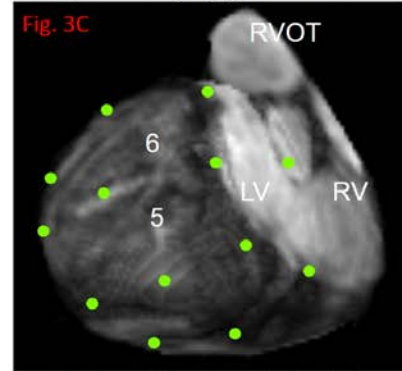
A) Standard 17-segmented scheme. In this example 8th and 9th segments include fibrosis. Therefore they are marked with a read outline. B) Example of revealing fibrosis only in 8th and 9th segments using MRI data. C) The same example of a reconstructed epicardial polygonal model. 5th and 6th segments do not include fibrosis.
